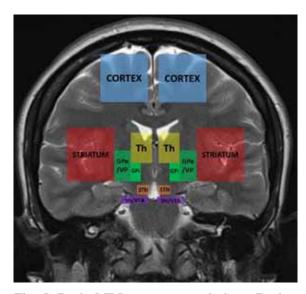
Brain MRI scan – coronal views. Region highlighted represented approximate location of the important areas involved in MDD (personal collection).
